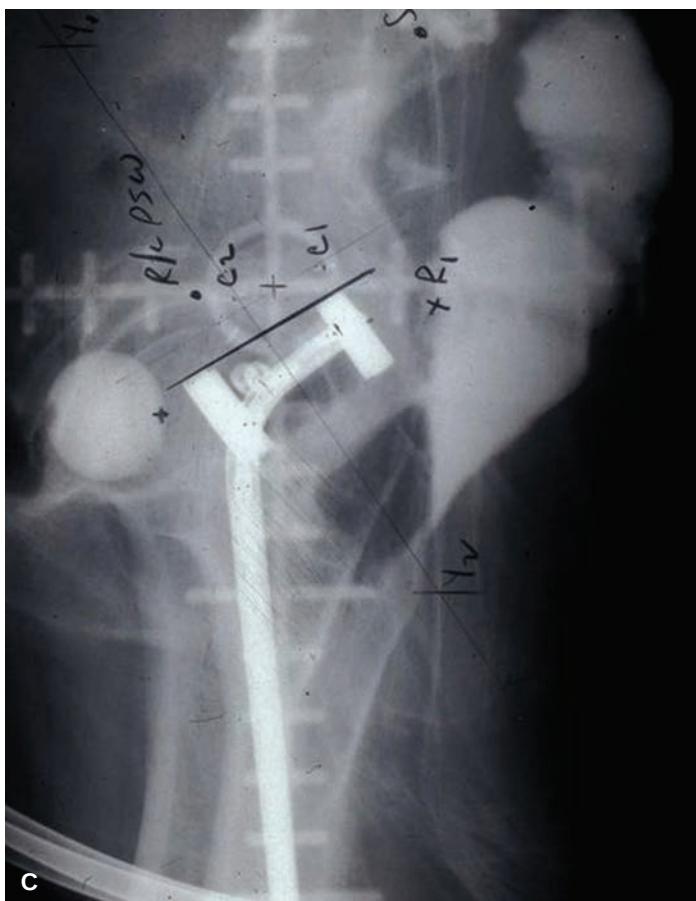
(continued) B: Low-dose-rate Fletcher ovoids with associated radiograph. Lateral radiographs are shown of cylinder C: and ovoids D: with bladder bulb contrast in both and rectal contrast in C:. CT-based dosimetry for a vaginal cylinder revealing the relationship of the dose distribution to the cylinder surface and adjacent bladder and rectum.
